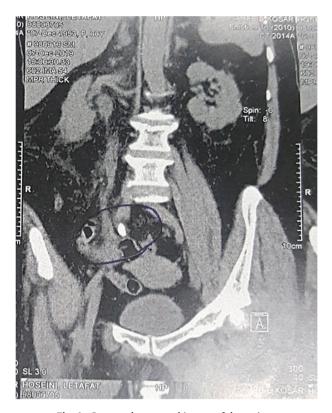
Computed tomographic scan of the patient.
